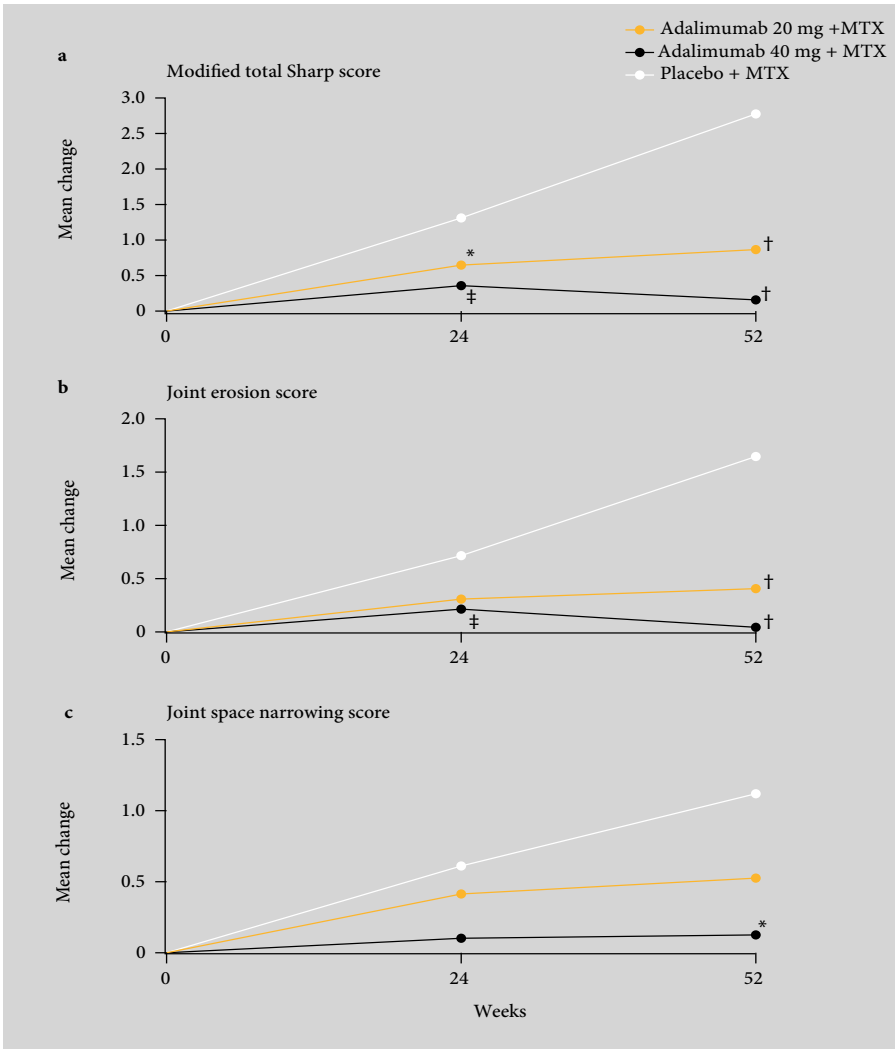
Mean changes from baseline to Week 52 in the (a) modified total Sharp radiographic progression score (extrapolated data), (b) erosion scores (last observation carried forward [LOCF] data), and (c) joint space narrowing scores (LOCF data) among the patients receiving adalimumab 40 mg every other week plus methotrexate (MTX), adalimumab 20 mg weekly + MTX, and placebo + MTX. * $P \leq 0.01$; † $P \leq 0.001$; ‡ $P \leq 0.05$ versus placebo (by analysis of covariance, baseline value are the covariates). Adapted with permission from Keystone et al [32] ©Wiley.
